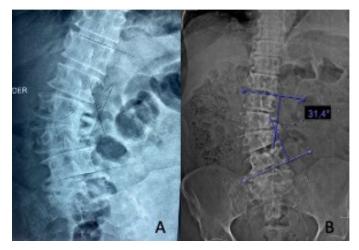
A) AP x-ray with degenerative lumbar scoliosis a L4 apex and 40° Cobb angle, L3-L4 and L4-L5 laterolisthesis and B) Axial traction x-ray, showing reduction of scoliosis up to 31.4°.
